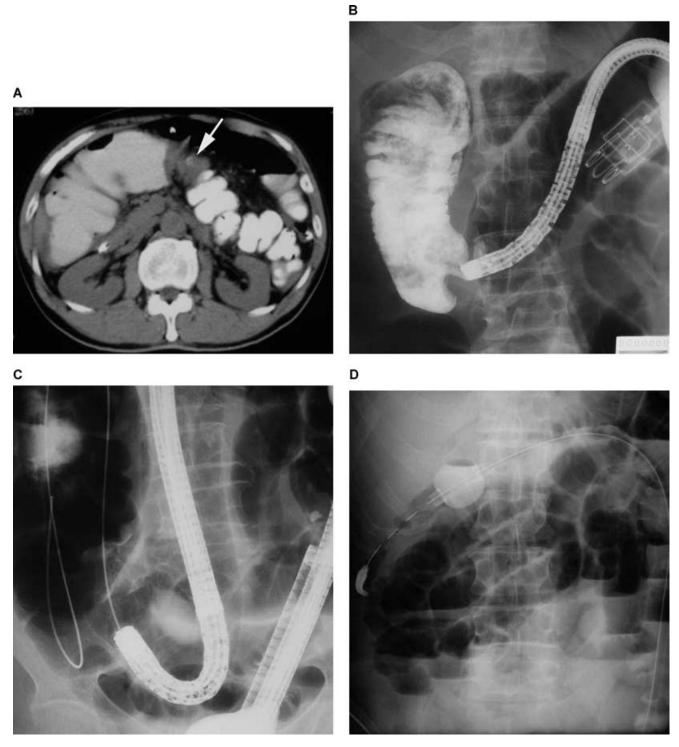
(*A*) Abdominal CT showing transverse colon carcinoma (arrow), (*B*) radiograph showing the site of obstruction in the transverse colon, (*C*) radiograph showing a flexible guidewire introduced through the tumor under a colonoscope on which the sliding tube (overtube) is held, and (*D*) radiograph showing the Dennis Colorectal Tube (DCT) positioned proximally to the tumor.
